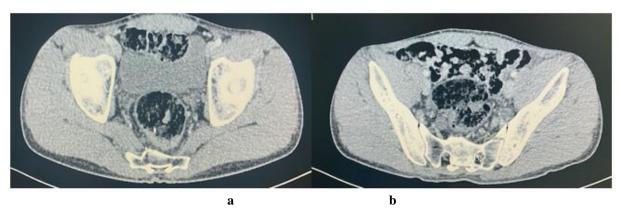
Axial abdominopelvic CT scan showing (a) subtle infiltration of the perirectal fat and (b) four mesorectal lymph nodes, the largest measuring 5×8 mm
